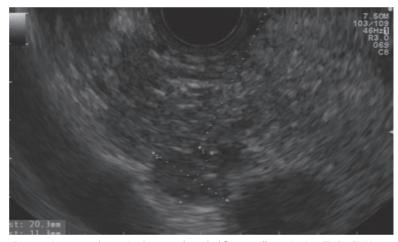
Pancreatic cyst: endoscopic ultrasound-guided fine needle aspiration (EUS – FNA) was not done because of the distance between the point of entry to the pancreas and the cyst was too great.
